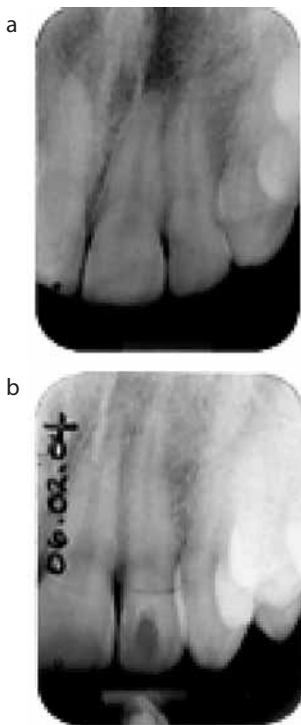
(a) Radiograph taken on first examination showed no root fractures. (b) Radiograph taken the following day clearly showed horizontal crown root fracture.
